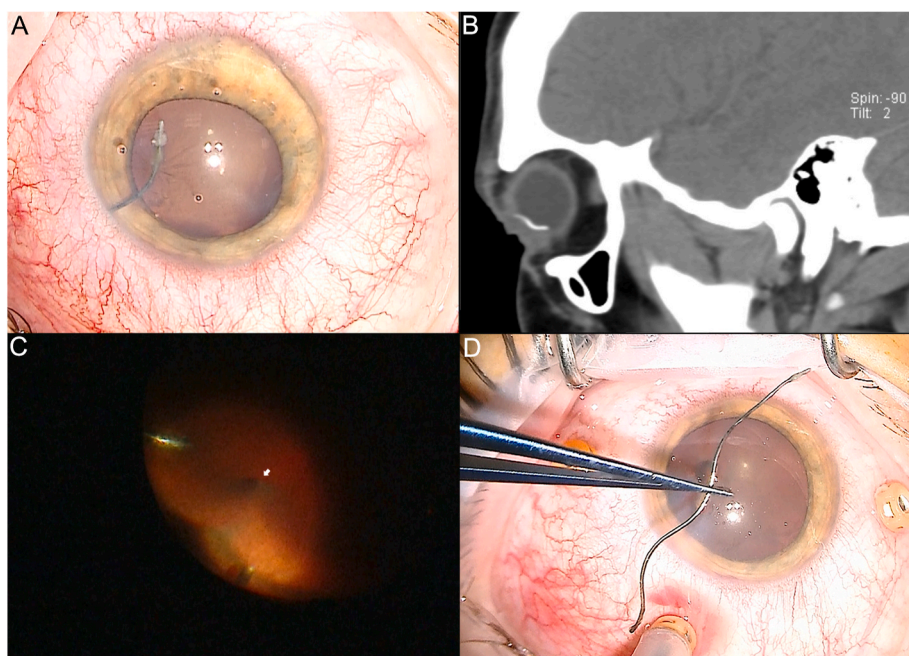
Suprachoroidal Intraocular Foreign Body. Intraocular foreign body (IOFB) with penetration through the cornea, tracking through the anterior chamber towards the angle (pupil pharmacologically dilated) (A). CT scan demonstrating posterior extension of metallic IOFB (B). Intraoperative photo demonstrating an irregular contour on scleral depression (arrow), indicating the presence of an IOFB underneath intact retina (C). Successful removal of 22 mm IOFB through self-sealing corneal entry wound (D).
